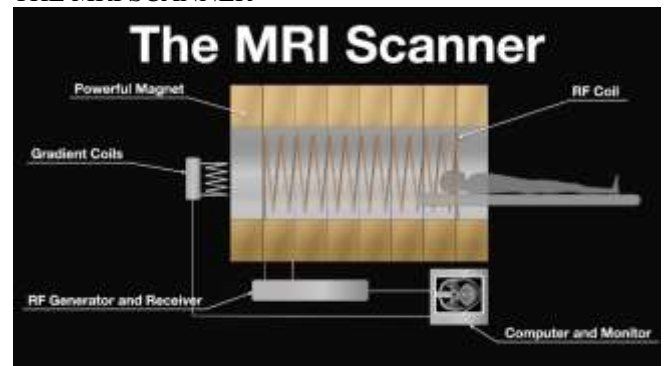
The MRI Scanner
